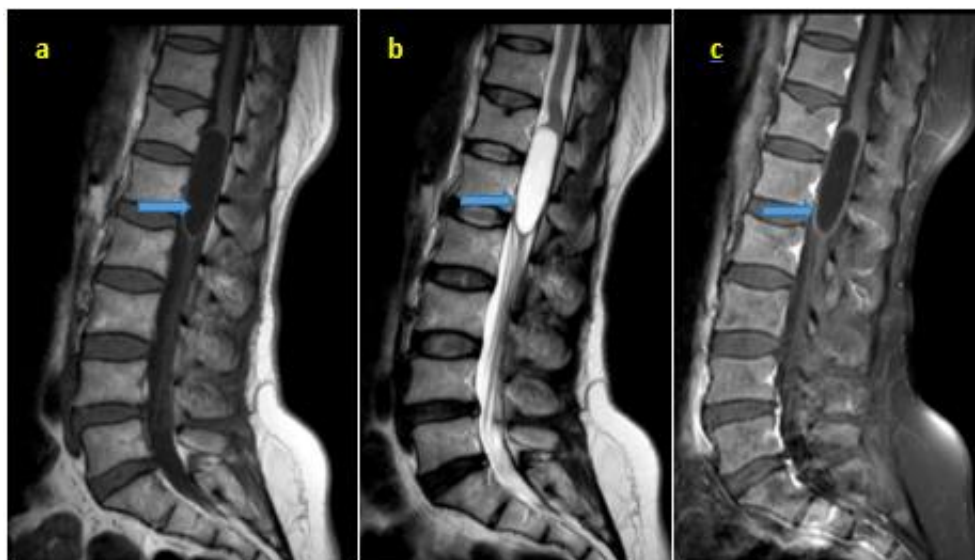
[a, b, c]: Sagittal plane of MRI showing intracanalicular intramedullary cystic in a low signal intensity on T1-weighted images [a] and high signal intensity on T2-weighted images [b], without enhancement after gadolinium administration [c]
